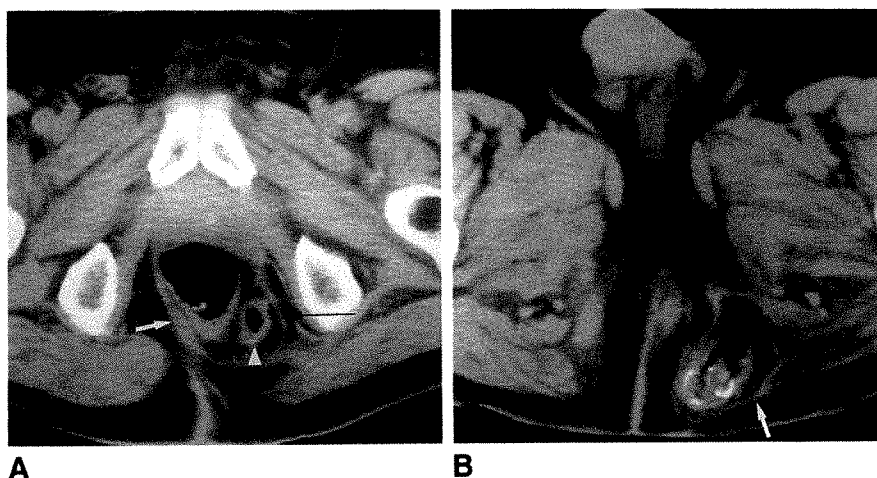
Perineal hernia in a 62-year-old man. A, CT scan of lower pelvis shows loop of sigmoid colon (arrowhead), surrounded by fat and hernia sac (black arrow), in left ischiorectal fossa, adjacent to rectum. Normal levator ani muscle is seen on right (white arrow) but not on left side.
